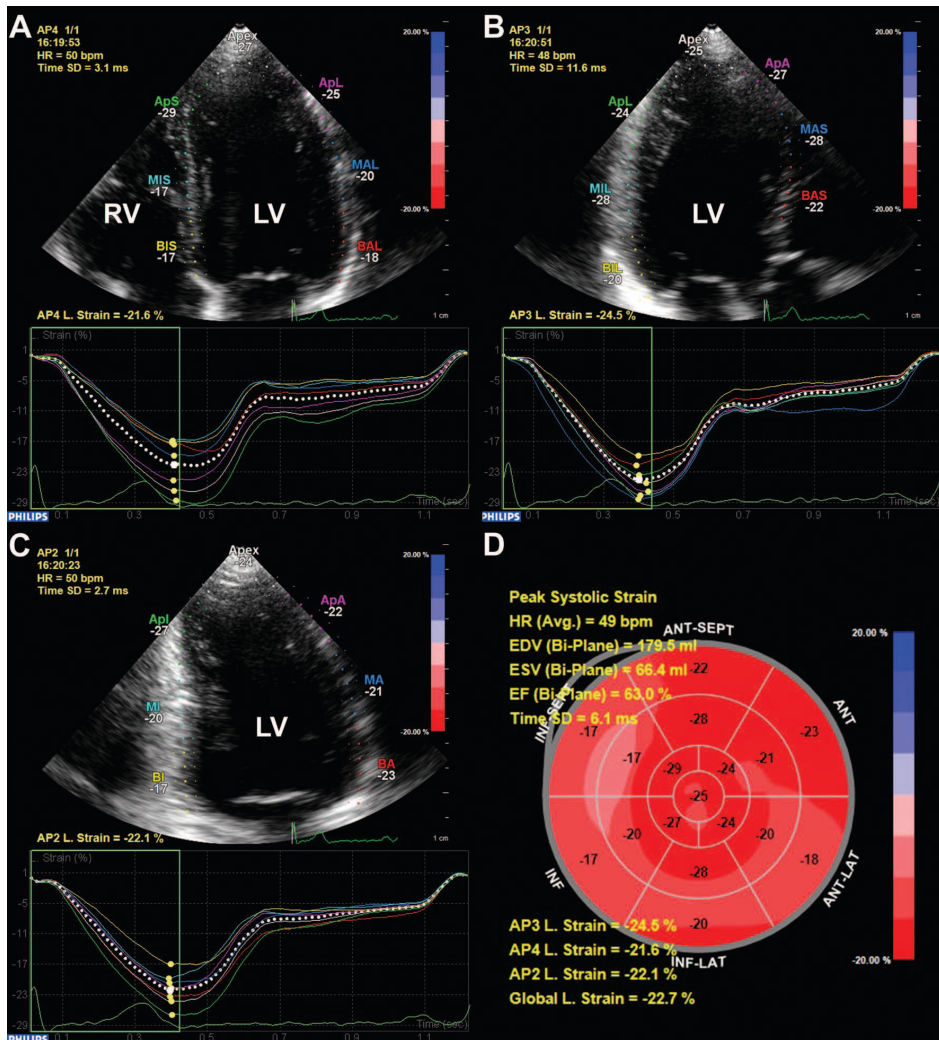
Example of left ventricular longitudinal strain measurements in a healthy individual. The left ventricle was traced in the apical four-, three-, and two-chamber views at end-diastole. The walls were automatically divided into seven segments at each view, and the global longitudinal strain at each view was calculated (A-C). The segmental strains were plotted in a bull's eye, and the left ventricular global longitudinal strain based on a 17-segment model was calculated (D). AP2=apical two-chamber; AP3=apical three-chamber; AP4=apical four-chamber; GL=global longitudinal; LV=left ventricle; RV=right ventricle
